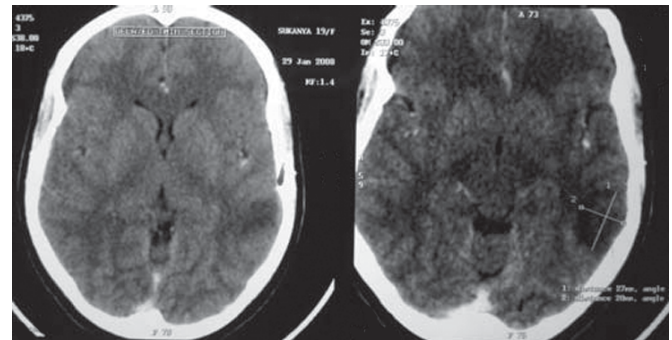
Plain CT scan of the head showing hypodense lesion (venous infarct) in the left temporal lobe
